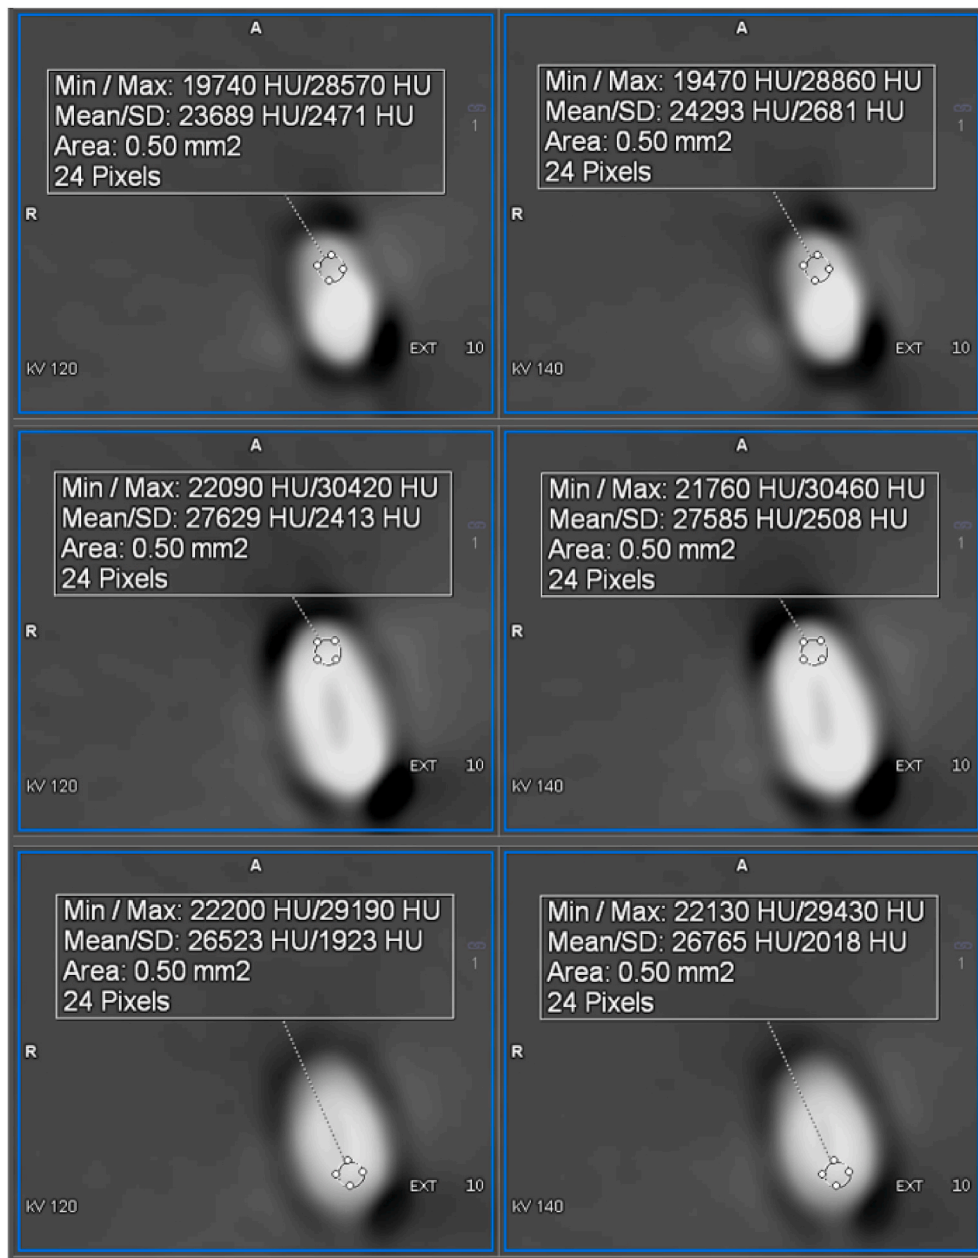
The mean value of the DEIs from maximum CT numbers within ROIs in three different slices of the images obtained with 120 kVp (left column) and 140 kVp (right column) was -0.003 (SD: 0.002). The DEIs are consistent with those from lead bullets, which supports the visual assessment of the removed fragments during the external examination.
